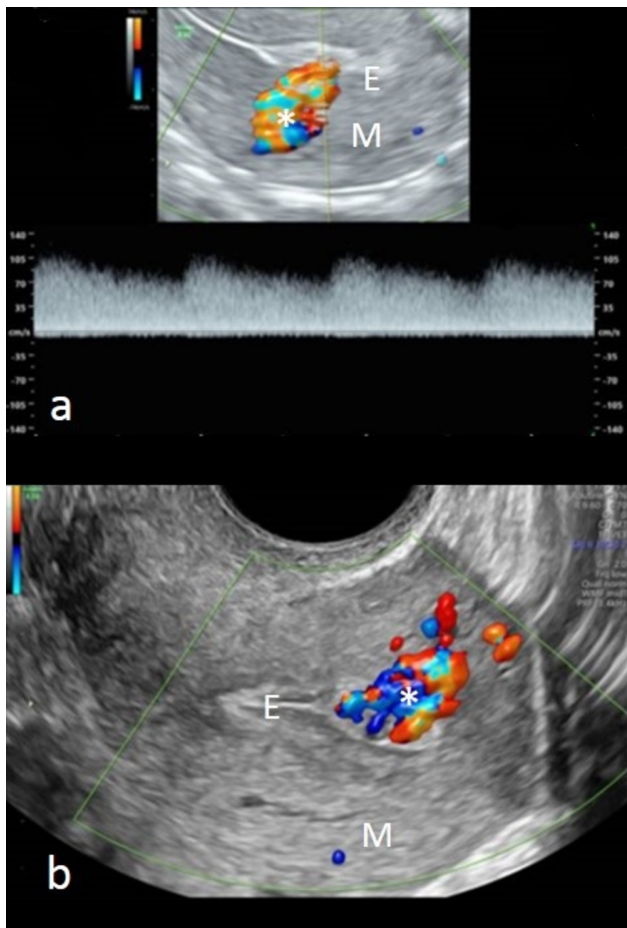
Power Doppler imaging of uterus of two different women presented with intermittent bleeding. The images show enhanced myometrial vascularity (asterisk) with vessels entering from the myometrium (M) to the endometrial cavity (E). In both cases RPOC was suspected. (A) The woman underwent diagnostic hysteroscopy which showed RPOC, followed by uneventful operative hysteroscopy (Patient 4). (B) Diagnostic hysteroscopy detected a tissue suspected as RPOC with active arterial bleeding. MRA was conducted and raised the suspicion of AVM. AVM was treated by UAE. After the embolization uneventful operative hysteroscopy was conducted (Patient 5).
